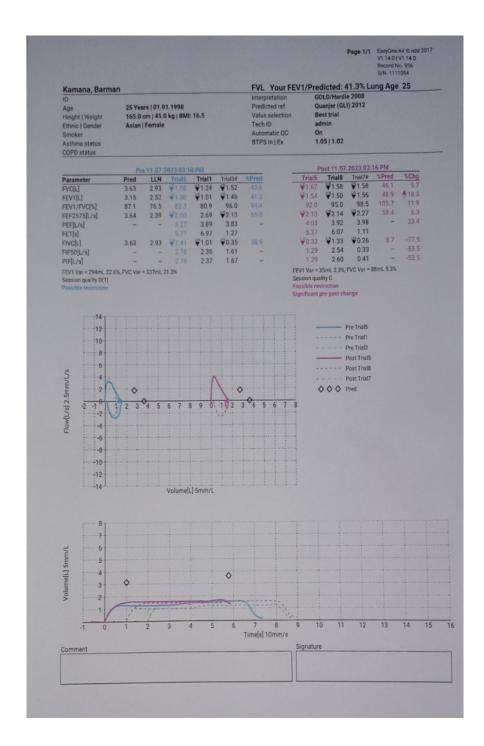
(a) chest X-ray at presentation (b) chest X-ray at discharge (c) spirometry at first visit (only visit)
